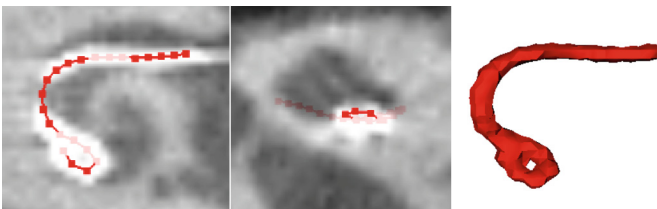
Coronal view (left) and axial view (middle) of electrode array tip fold-over in a postoperative CT. 3D rendering (right) of a folded over electrode array.
